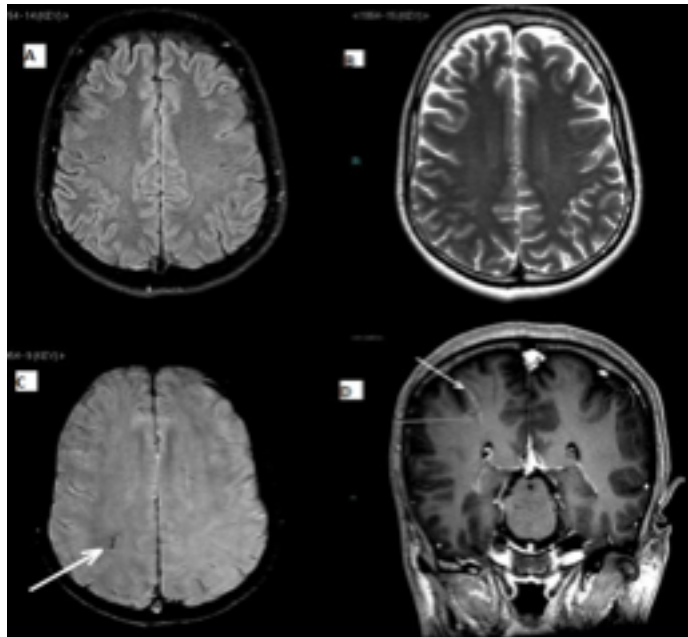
Selected MR brain images of a patient showing (a) axial FLAIR and (b) axial T2W images (upper row), (c) axial SWAN image, and (d) contrast-enhanced coronal T1W images (bottom row). Note that the vascular malformation (in this case, a venous angioma) is seen as a linear enhancing structure (d) reaching the subcortical parietal lobe that was a small branching black structure on SWAN image (c).
